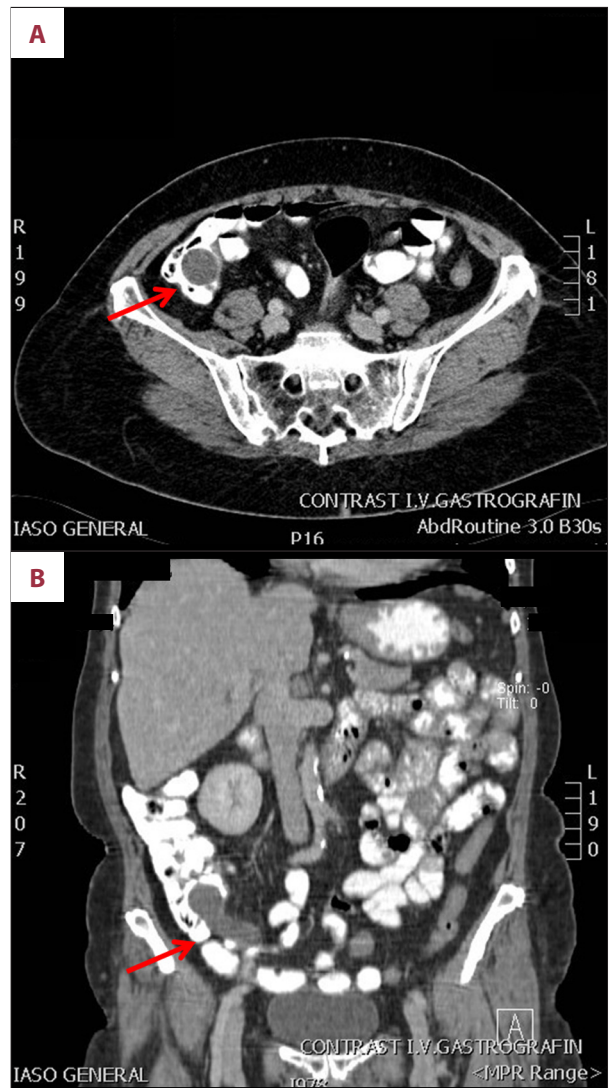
(A, B) CT scan indicating a well-defined appendiceal mucocele (arrows).
